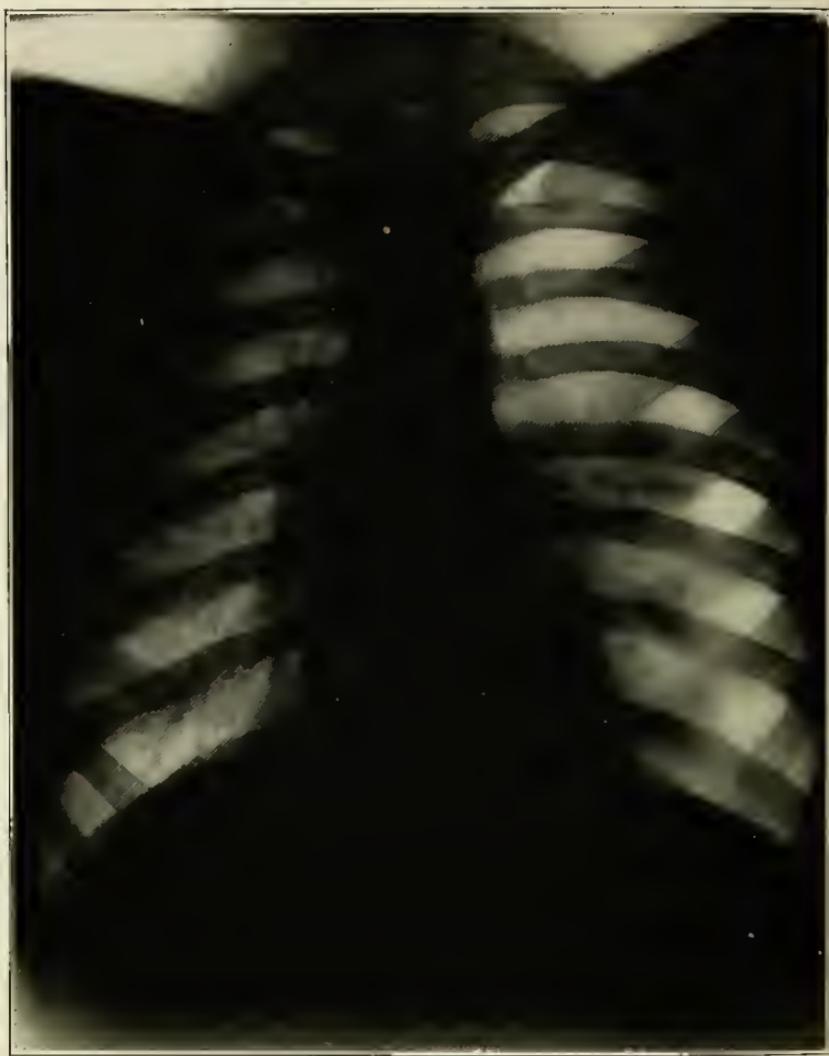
Dec. 16, 1921. X-Ray of the thorax showing the left lung expanded approximately to two-thirds of its normal size.
